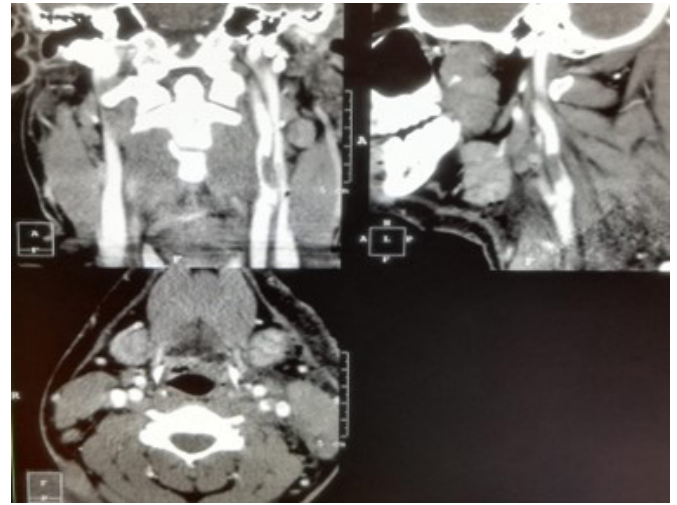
CT angiogram of the neck at presentation in coronal, sagittal, and axial views showing traumatic thrombosis involving the left internal carotid artery at the C3-C4 level, occupying 80% of the lumen circumference along a 2.2 cm length; intimal flap in the distal part of the left common carotid artery just behind its bifurcation; left-sided, deeply located hematoma measuring 11x17 mm at the site of the previously described vascular injury; surgical emphysema; and no evidence of active extravasation or pseudoaneurysm formation.
